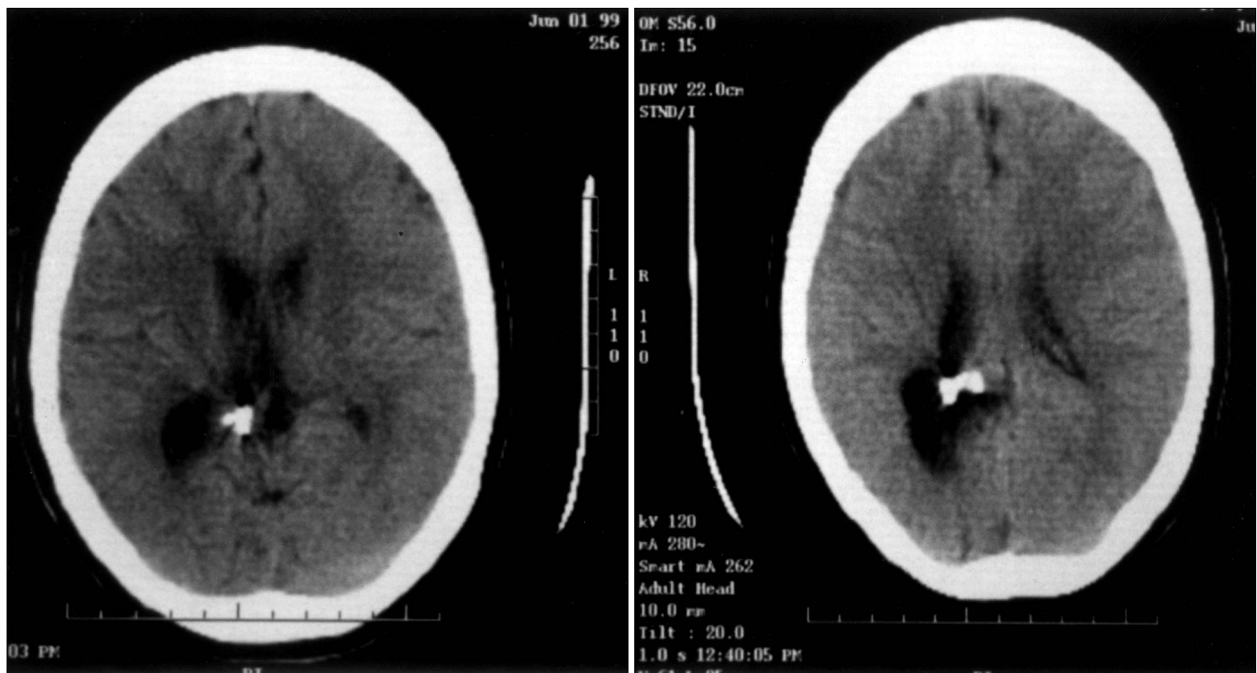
Postoperative CT scan showing preservation of visual cortex.
